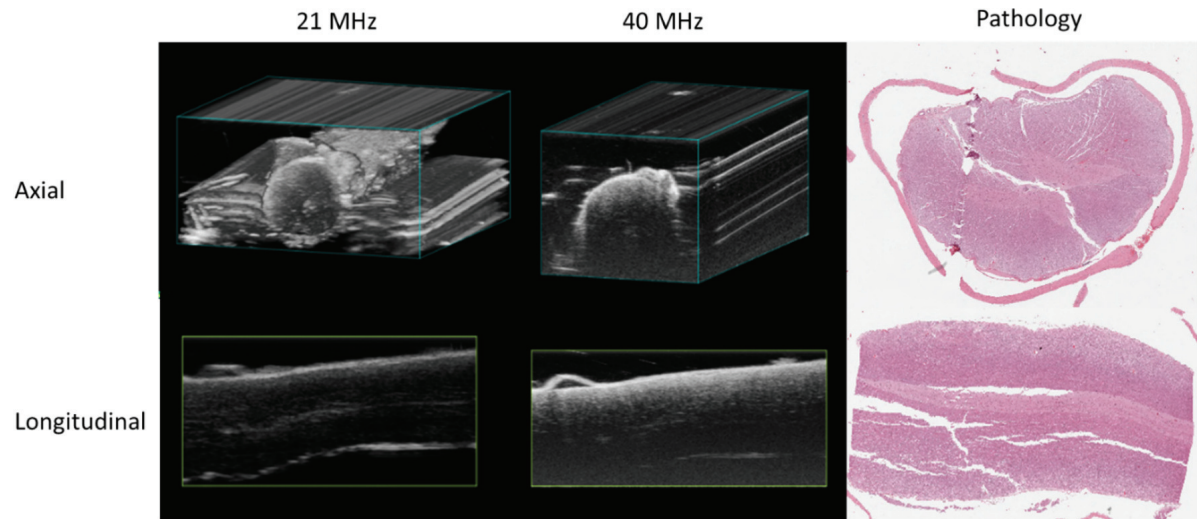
Axial and longitudinal high frequency micro-ultrasound images with central frequencies of 21 MHz and 40 MHz accompanied by representative pathological slides.
